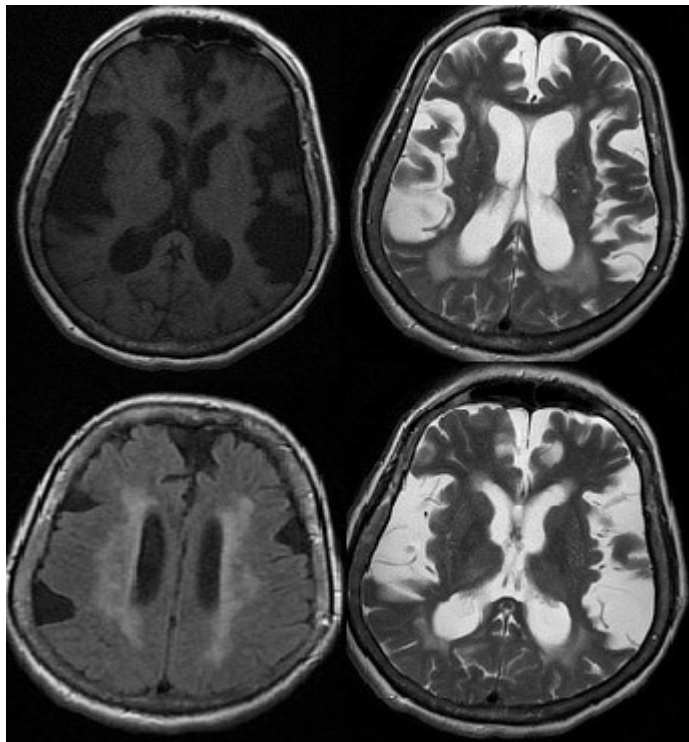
Brain MRI showed widening of bilateral cerebral hemisferes due to atrophy
